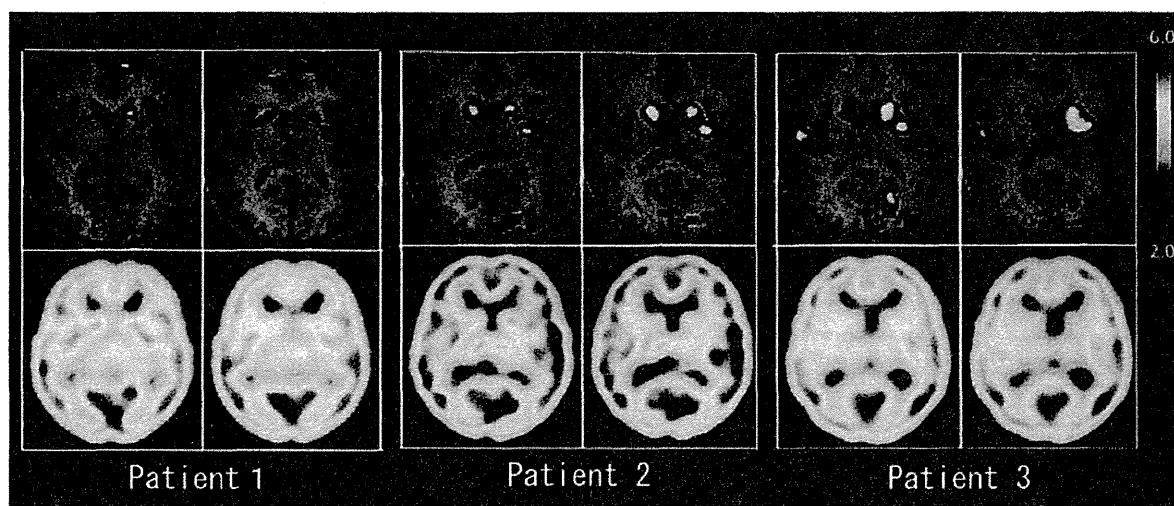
ECD-SPECT and eZIS results. Usual color images of ECD-SPECT in three patients were shown on the lower figures in each patient. Analyzed images using eZIS were shown on the upper figures. The converted images indicate regions of decreased cerebral blood flow by colors from blue (2.0 standard deviation) to red (6.0 standard deviation). Reduction in cerebral blood flow was shown most common and prominent in the bilateral caudate nuclei in all three patients.
